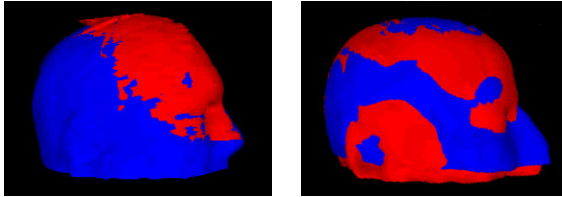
Three-dimensional skull reconstruction of CT and MRI images
